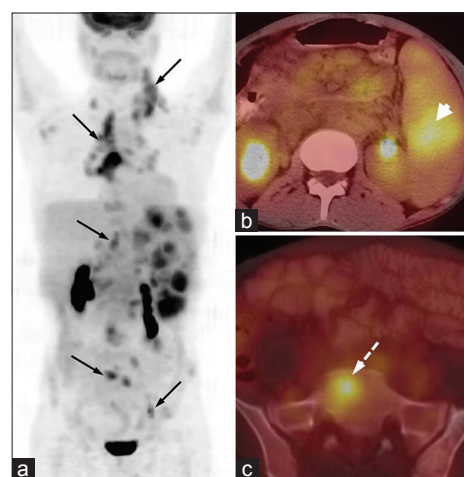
(a-c) An 18-year-old male with Castleman's disease. Maximum intensity projection positron emission tomography (PET) image (a) revealed multiple enlarged ¹⁸F-2-fluoro-2-deoxy-glucose avid cervical, axillary, mediastinal, retroperitoneal and inguinal lymph nodes (arrows). Transaxial PET/computed tomography images demonstrating splenic (b, arrowhead) and bone marrow (c, broken arrow) involvement
